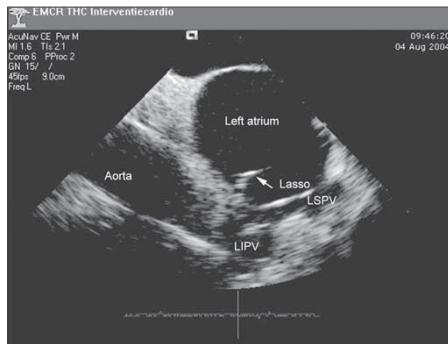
Phased-array intracardiac echocardiogram: circular multipolar catheter (Lasso) in the antrum of the left inferior pulmonary vein. LIPV=left inferior pulmonary vein, LSPV=left superior pulmonary vein.
